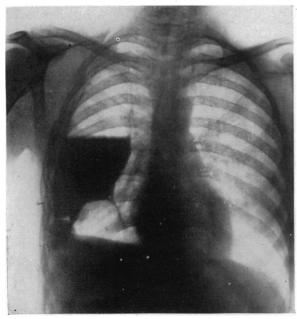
Case II. Anteroposterior X-ray following lipiodol injection with the cavity half filled, showing a prolongation of the cavity mesially.
